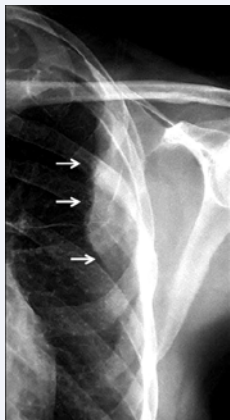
Chest X-ray shows well-defined homogeneous opacity in the left chest wall (arrows).
